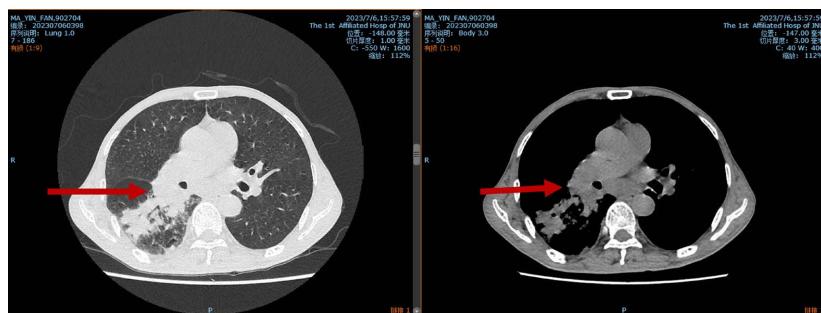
Chest CT Image from July 6, 2023. Enlargement of the right hilum, narrowing of the lumen of the right main bronchus, multiple patchy opacities in the right lower lobe, multiple enlarged mediastinal lymph nodes, and consideration of neoplastic lesions is warranted
